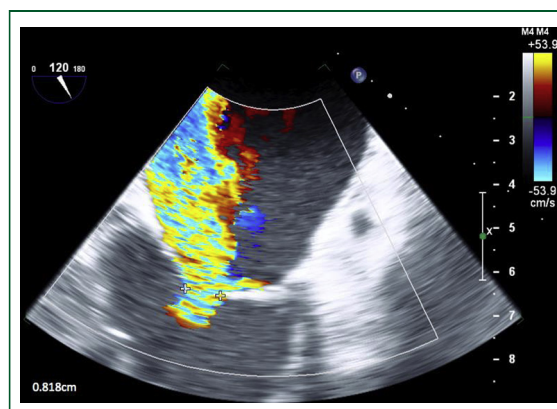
A point-of-care transesophageal echocardiography exam in a patient with shock in the context of an acute coronary syndrome demonstrates an eccentric jet along the left wall of the left atrium. Vena contracta is measured at 8 mm, which is indicative of severe mitral regurgitation.
